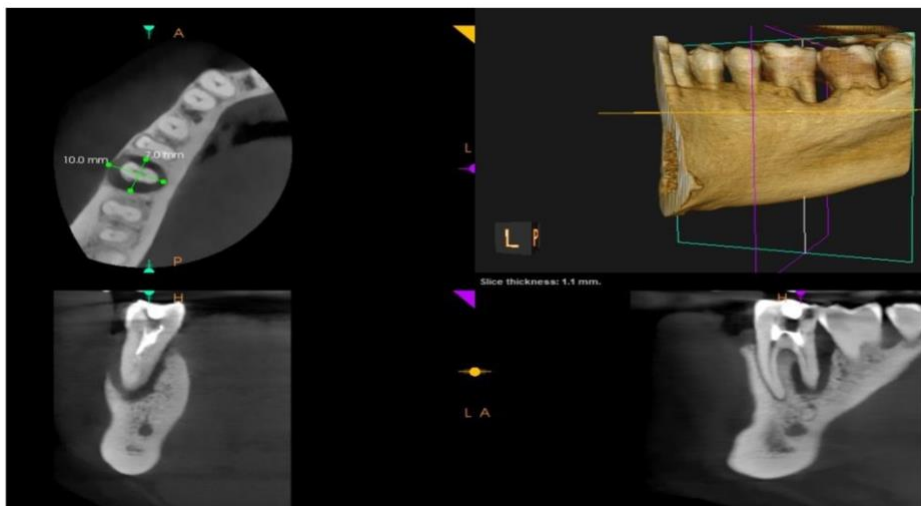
Case 2. CBCT images of tooth #46. Axial, sagittal, and coronal sections reveal an extensive radiolucency surrounding the distal root and extending into the furcation, with loss of the buccal and lingual cortical plates. The scans confirm a localized defect, absence of a vertical root fracture, and an intact mesial root.
